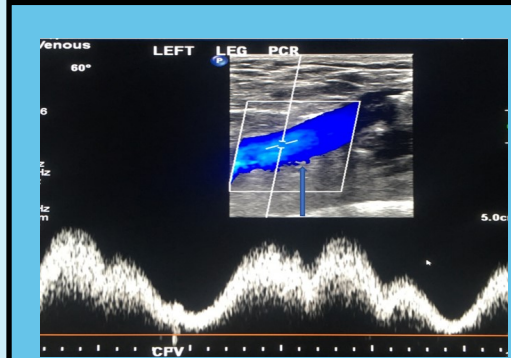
Fills in with color on Doppler.
